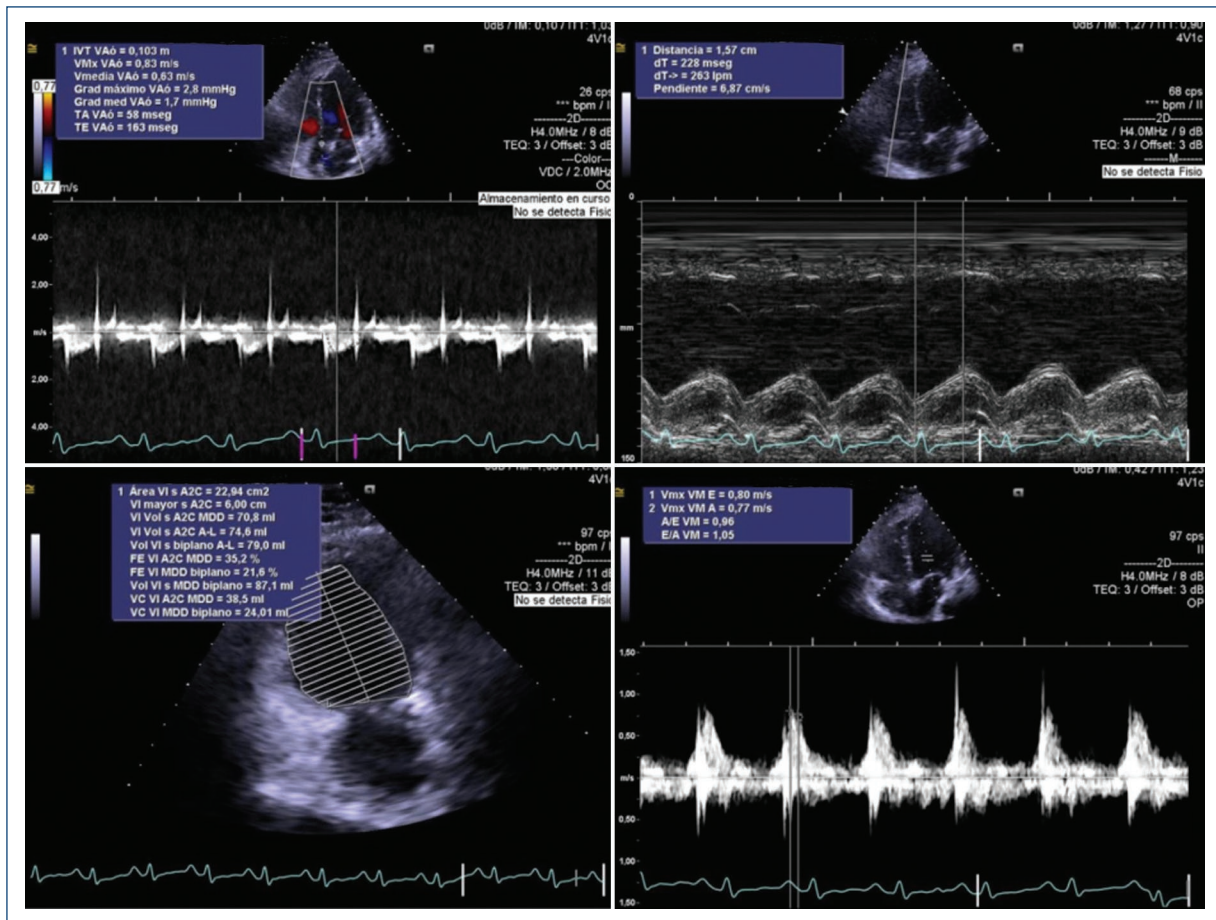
Transthoracic echocardiogram. Four days after surgery. Systolic dysfunction with severe myocardial damage, with non-dilated, non-hypertrophic left ventricle, generalized hypokinesia, with calculated LVEF by Simpson's method at 22%, 3D LVEF at 27% with a global longitudinal strain of -9% . These findings are consistent with stress cardiomyopathy (likely systolic dysfunction induced by sepsis). Diastolic dysfunction without an increase in filling pressures. LVEF: left ventricular ejection fraction.
